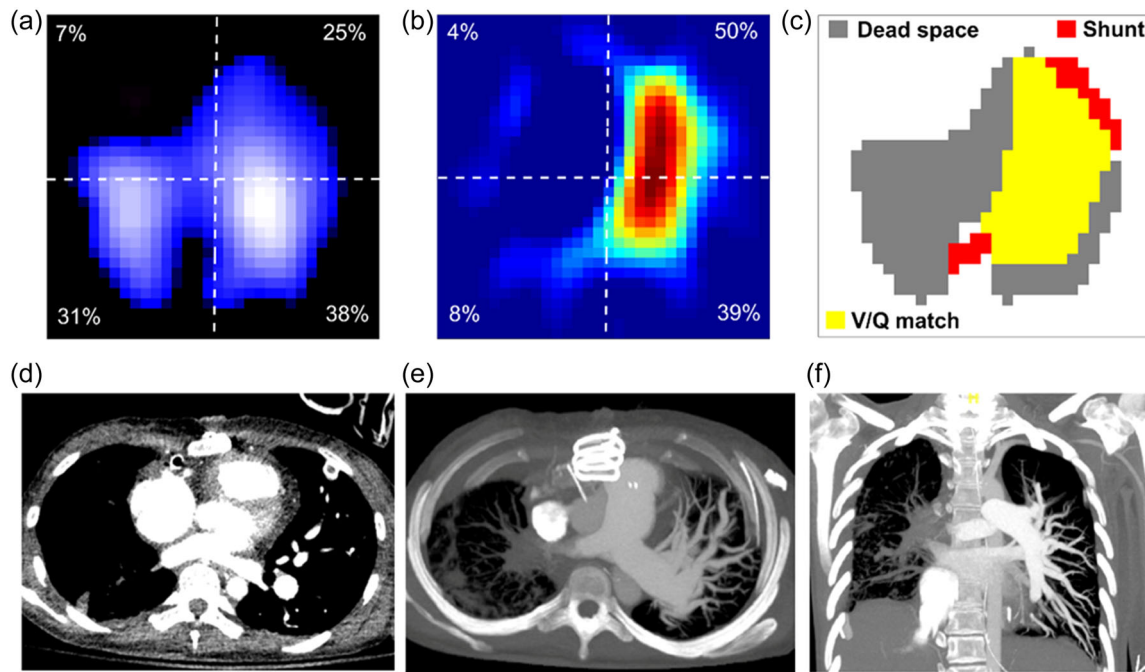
The results of electrical impedance tomography (EIT) and CT pulmonary angiography (CTPA) showing perfusion defects of the patient. (a) Functional EIT image of ventilation distribution. Regions with low ventilation are marked in the dark blue, and regions with high ventilation are marked in white. (b) Functional EIT image of perfusion distribution measured by injecting 10 mL of 10% saline bolus during respiratory hold. Regions with high perfusion are marked in red and regions with low perfusion are marked in blue. (c) Functional EIT image showing the distribution of regional ventilation/perfusion ratios. Ventilated regions were defined as pixels with impedance changes of more than 20% of the maximum tidal impedance variation in the functional ventilation image. Perfused regions were defined as pixels with more than 20% of the maximum bolus-related impedance change in the functional perfusion image. Regions with high ventilation and low perfusion are marked in gray (corresponding pixels show the ventilated but not perfused regions). Low ventilation and high perfusion regions are marked in red (corresponding pixels show the perfused but not ventilated regions). Good ventilation-perfusion matching is marked in yellow (pixels belong to both regions and exhibit both ventilation and perfusion). (d–f) CTPA revealed that right pulmonary arteries were occluded. (d) CTPA scan; (e, f) 3-Dimensional reconstruction of pulmonary arteries at the horizontal and coronal planes.
